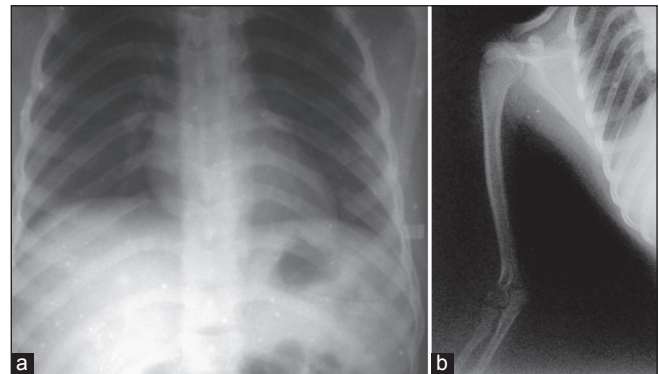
Preoperative X-rays of the chest (a) and upper limbs (b) were unremarkable
